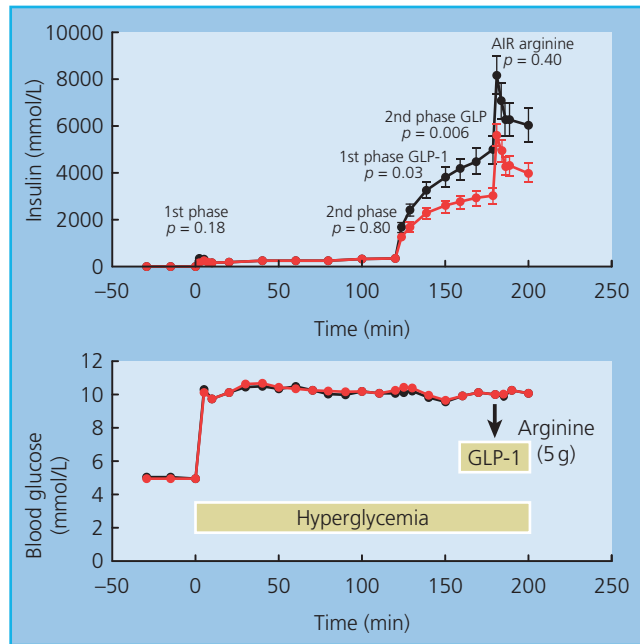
Associations between the genotypes of rs7903146 polymorphism in the *TCF7L2* gene with insulin secretion during a hyperglycemic clamp in 73 participants. Black lines, CC; red lines, CT and TT. AIR, acute insulin response. Arrow, administration of 5 g of arginine. The p values show the differences for the first- and second-phases of glucose-induced insulin secretion, first- and second-phases of GLP-1-induced insulin secretion, and acute insulin secretory response to arginine (AIR). Source: Schäfer et al. 2007 [31]. Reproduced with permission of Springer.
